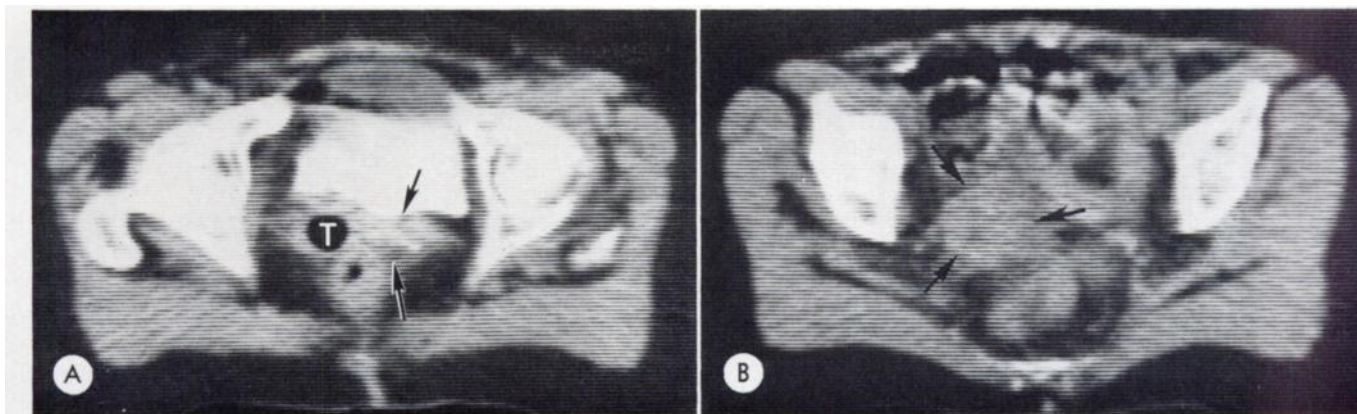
Case 1. *A*, CT scan showing tumor extension (*arrow*) to left of vagina, which is identified by tampon gas shadow (*T*). Rectum containing small amount of gas seen posteriorly, and contrast medium present in bladder. *B*, CT scan at level of superior limit of vaginal cuff (*arrows*) showing bulk of recurrent mass. Location obtained by following tampon gas shadow superiorly on sequential scans.
